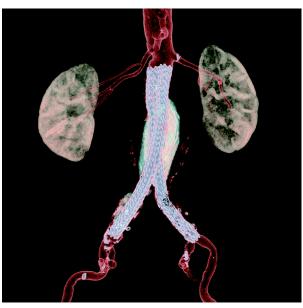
CTA reconstruction in patient 3 years after procedure. Aneurysms excluded from circulation. Endograft is stable and fixed in the aneurysmal sac, blood flow preserved to IIAs
